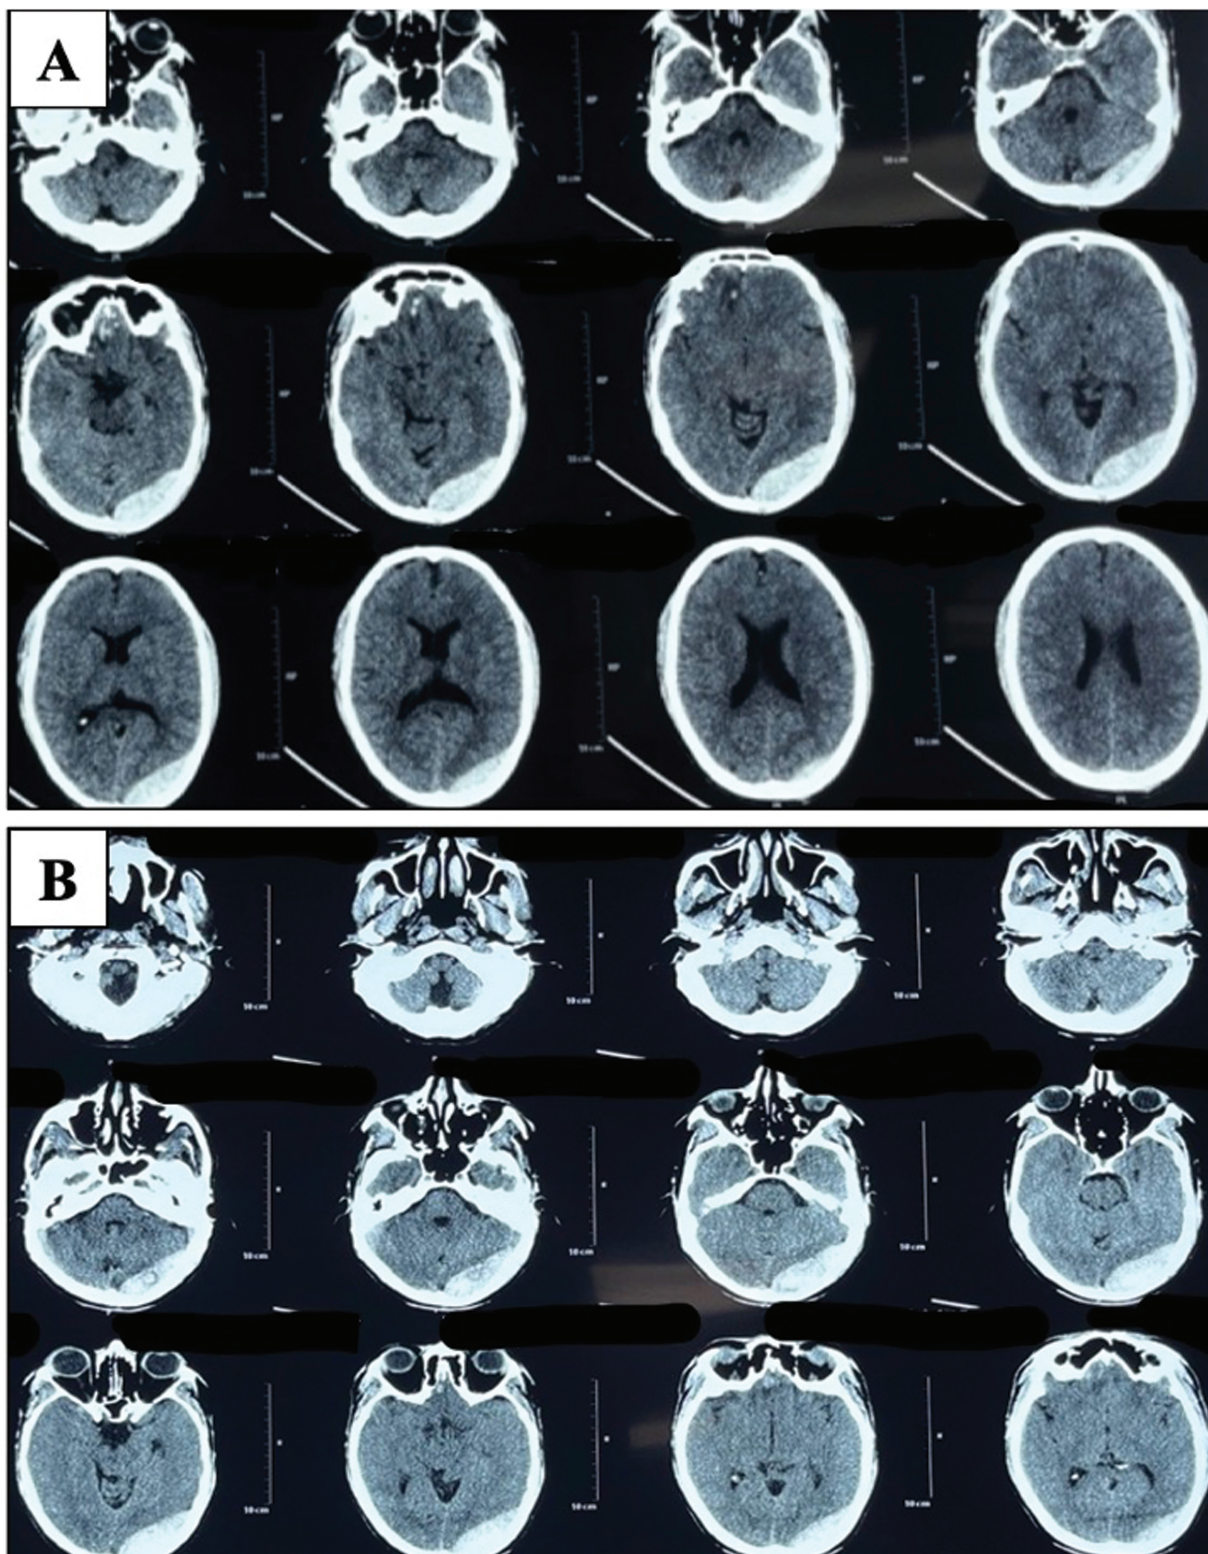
Plain computed tomography (CT) of the brain done at (A) 12 hours and (B) 6 days posttrauma showing bilateral occipital extradural hematoma (EDH).
